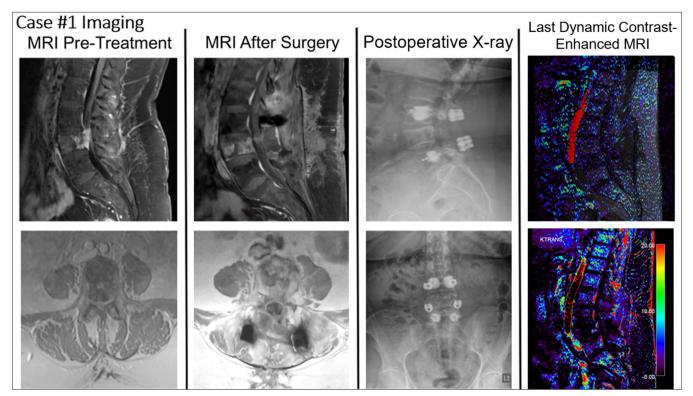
Relevant imaging for Case #1. The first column contains T1-weighted fat-suppressed magnetic resonance imaging (MRI) pretreatment (top = sagittal, bottom = axial). The second column contains T1-weighted fat-suppressed MRI after surgery (top = sagittal, bottom = axial). The third column contains X-rays after surgery (top = lateral, bottom = anteroposterior). The last column contains the last dynamic contrast-enhanced-MRI (top = overlay, bottom = MR perfusion).
